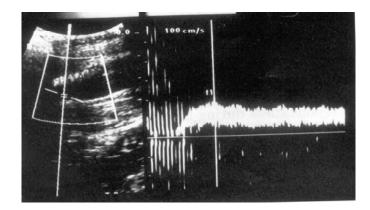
Sonographic measurement during a compression cycle of AVI.
